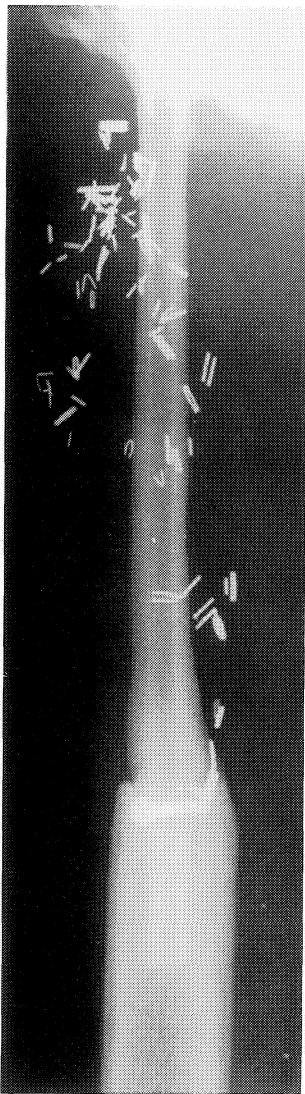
AP radiograph of a vascularized fibular spacer six months after resection.
